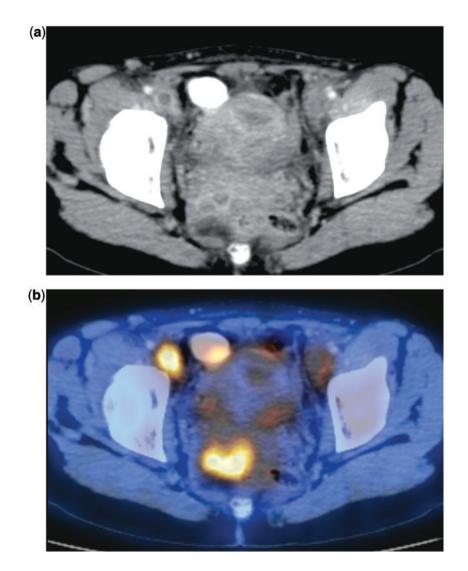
A 32-year-old woman with advanced-stage melanoma. (a) CT demonstrates a deep vein thrombosis in the right common femoral vein. (b) On PET/CT this lesion is seen as an area of increased FDG uptake, indicating its malignant nature.
